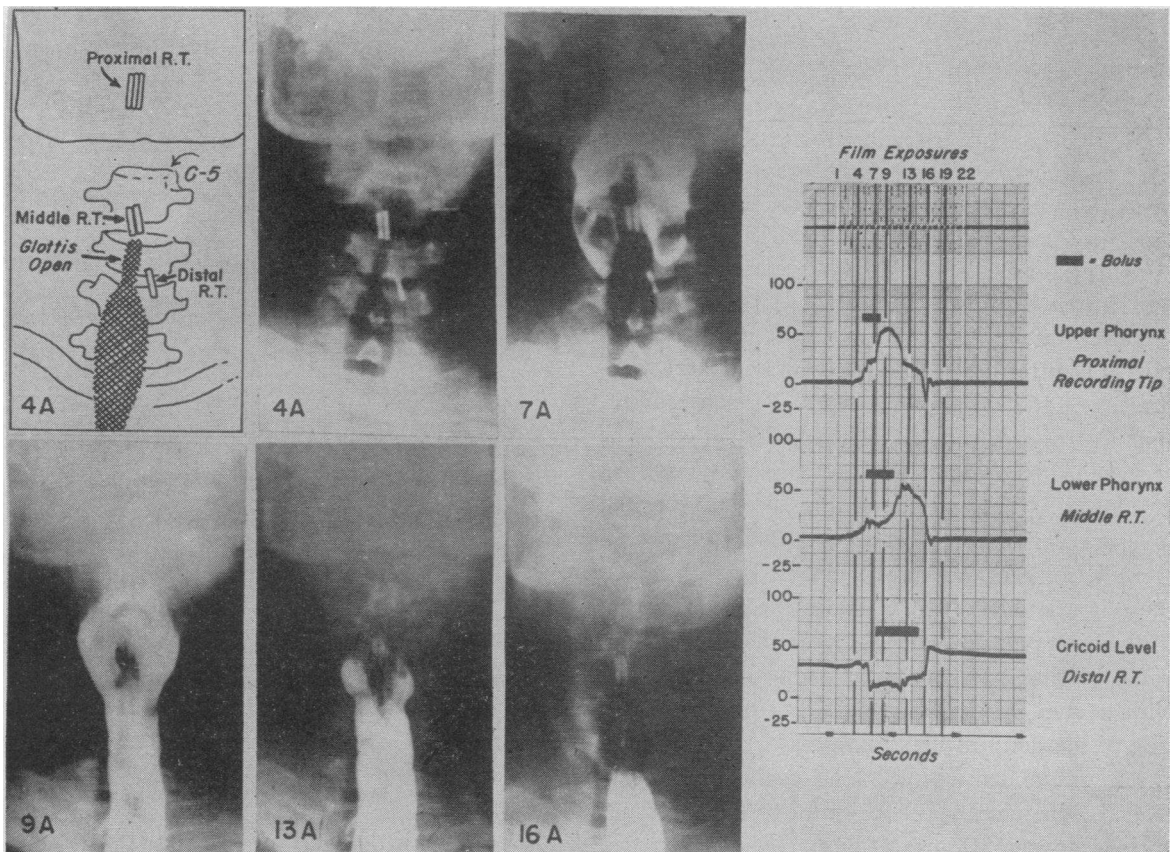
RADIOGRAPHS TAKEN DURING THE RECORDING OF INTRAPHARYNGEAL PRESSURE CHANGES ON SWALLOWING BARIUM SUSPENSION
